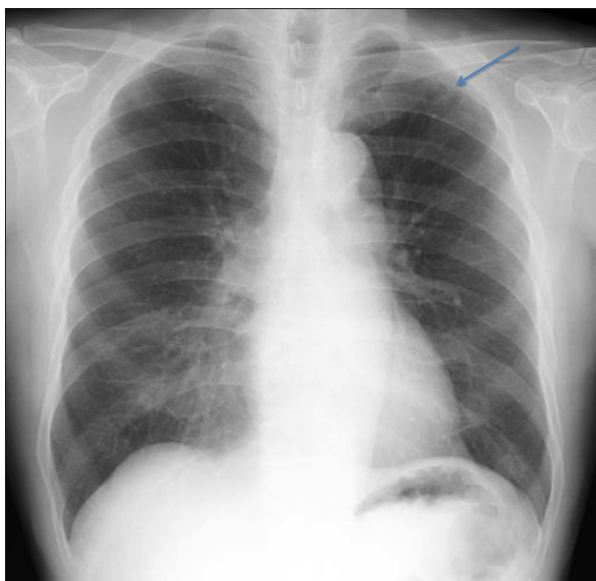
An X-ray showed an abnormal shadow in the apex of the left lung.
